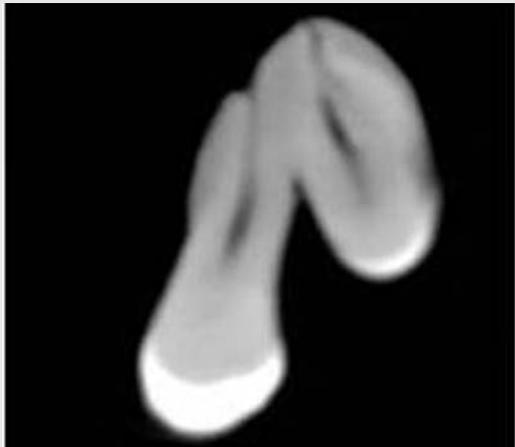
Coronal slice of CBCT showing concrescence.
